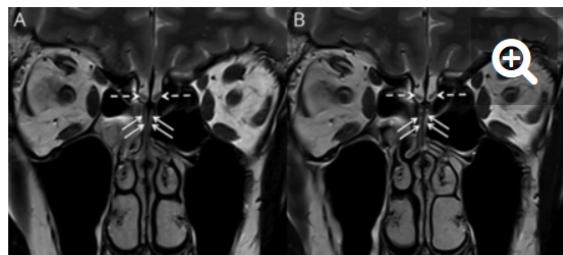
Patient 8: 53 year-old man with severe acute respiratory syndrome coronavirus 2 infection. Coronal section of the olfactory clefts and bulbs on MRI on 2D T2-weighted sequences. (A and B) On the first MRI, the olfactory bulbs (white dotted arrow) are normal (right 33.2 mm³, left 39.1 mm³), while a bilateral inflammatory obstruction (white arrow) of the olfactory clefts is observed. (C and D) At the 1-month follow-up, the volume of the olfactory bulbs (white dotted arrow) remains normal (right 38.2 mm³, left 41.9 mm³), but an inflammatory obstruction of the OC (white arrow) is still observed. The olfactory score at the first consultation and the 1-month follow-up was 0 and 5, respectively.
